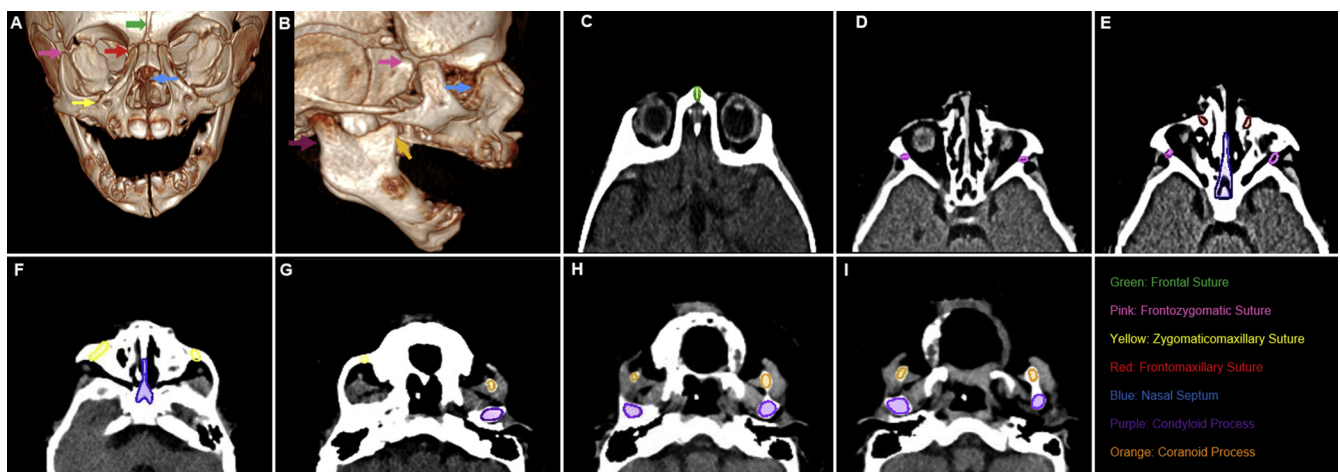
Craniofacial centers of growth depicted on an anterior (A) and lateral (B) 3-dimensional reconstructed computed tomography scan of an 8-month-old female infant. Also shown are axial computed tomography slices with contours of important centers for growth (C-I), progressing in the craniocaudal direction.
